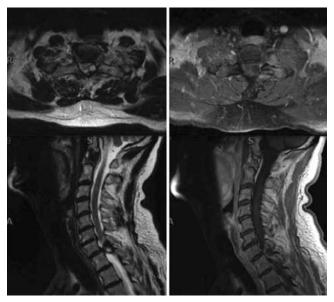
Case 1. Left: T2-weighted MR images showing a cystic formation at C7–T1. Right: T1-weighted MR images obtained after administration of a contrast agent showing enhancement of the cystic capsule.
